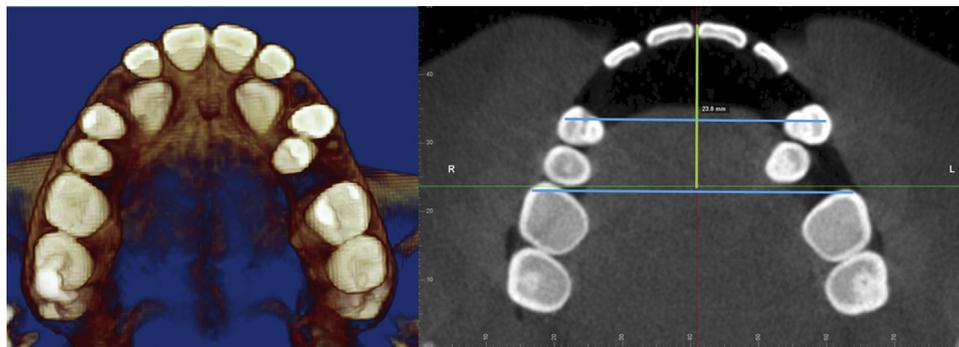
Measurements of the arch depth (green), interpremolar distance and intermolar distance (light blue) in the axial cut of the CBCT.
